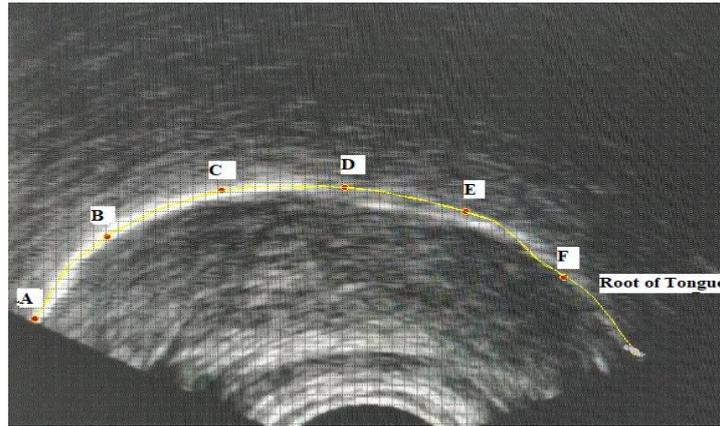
Segmented Ultrasound Image for the tongue rest position
